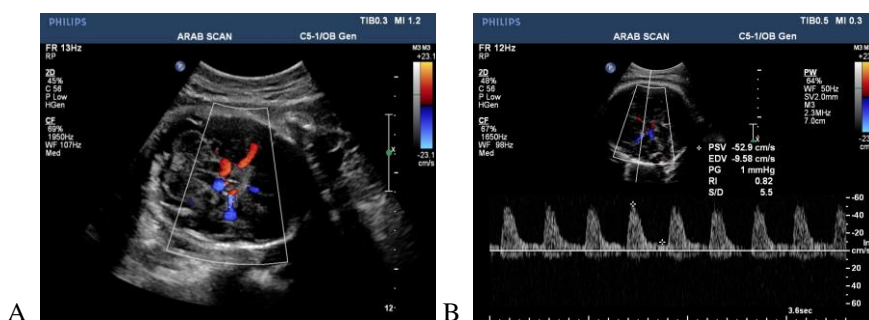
Showing identification of circle of Willis including Middle Cerebral Arteries and Doppler indices
